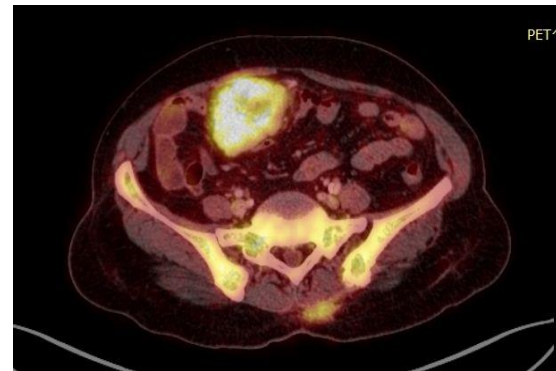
PET CT showing metabolically active ileal Lesion.
